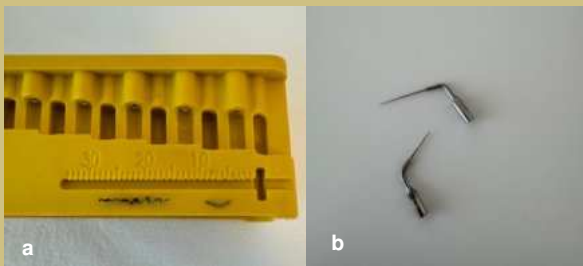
Fractured instruments(a), ultrasonic tips ED27 at the bottom and ED89 at the top (b).
